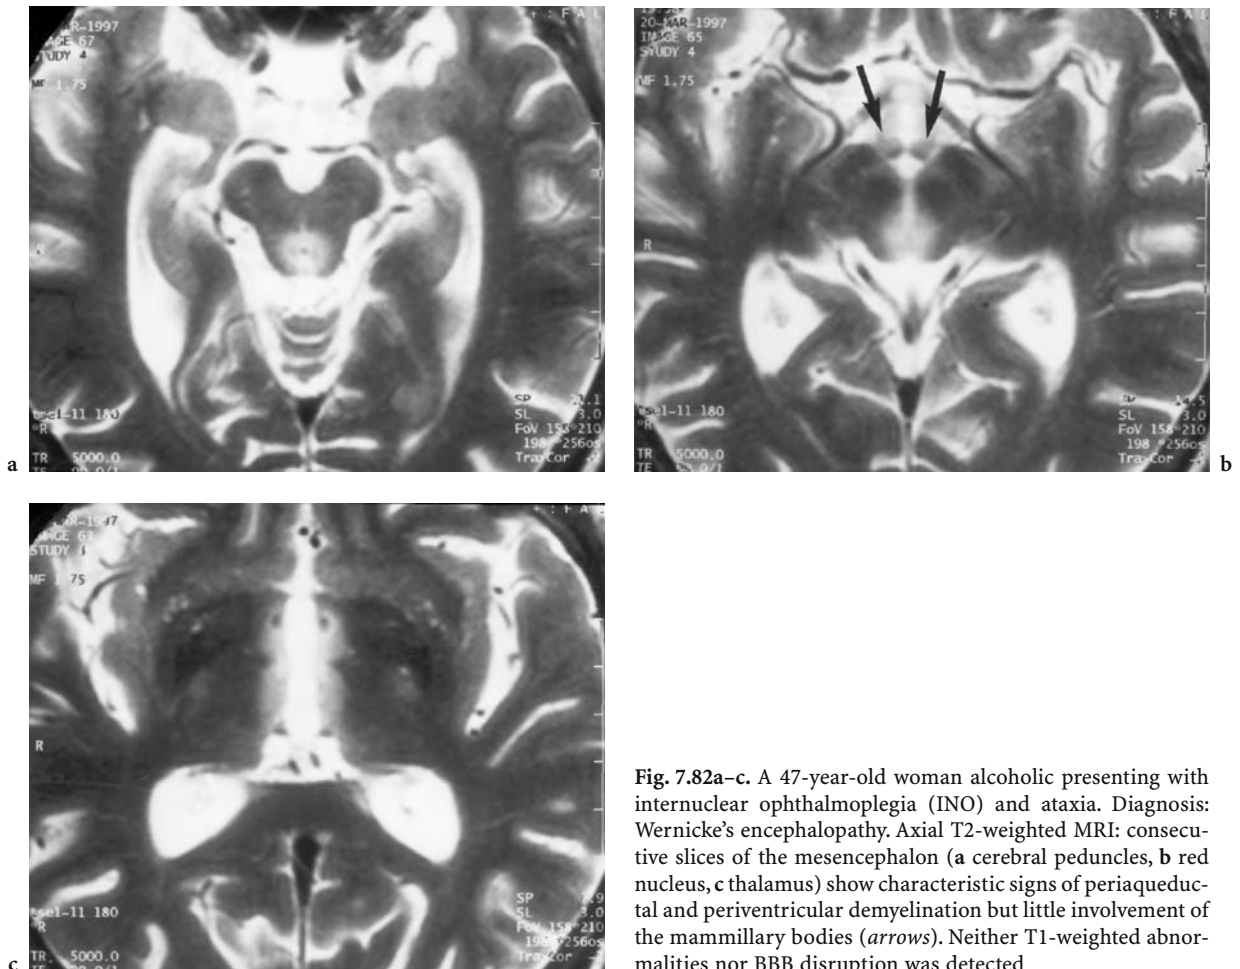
A 47-year-old woman alcoholic presenting with internuclear ophthalmoplegia (INO) and ataxia. Diagnosis: Wernicke's encephalopathy. Axial T2-weighted MRI: consecutive slices of the mesencephalon (a cerebral peduncles, b red nucleus, c thalamus) show characteristic signs of periaqueductal and periventricular demyelination but little involvement of the mammillary bodies (arrows). Neither T1-weighted abnormalities nor BBB disruption was detected
